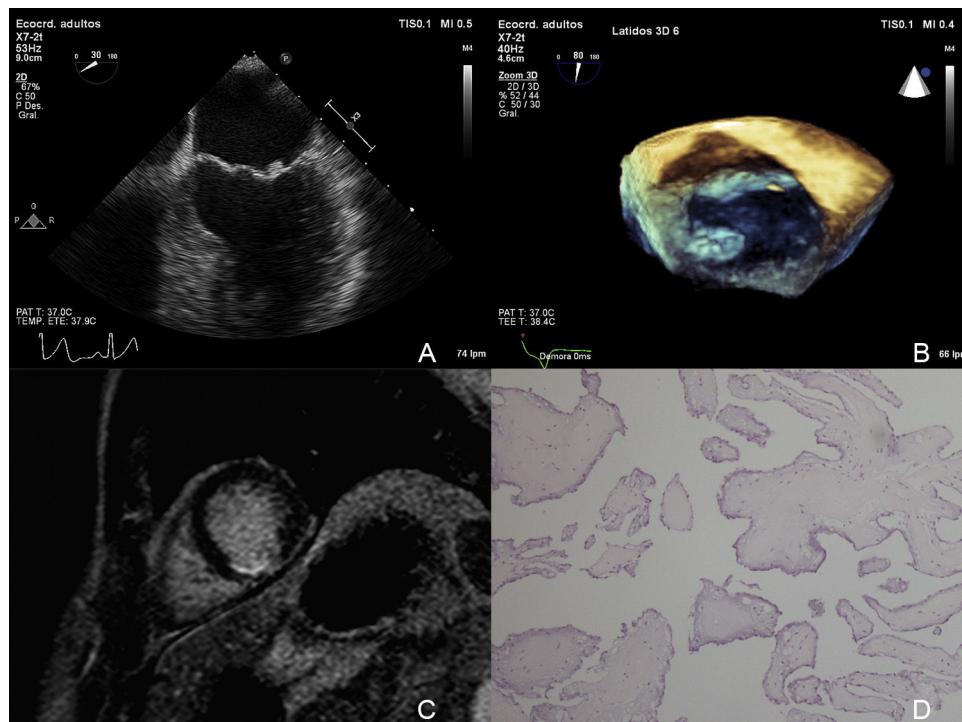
A and B: 2D/3D transesophageal echocardiogram showing the papillary fibroelastoma on the posterior leaflet (P1). C: magnetic resonance showing subendocardial infarct of the posterior septum and inferior wall. D: pathology showing papillary fronds of connective tissue with few cells, covered with a single layer of endothelial cells.
